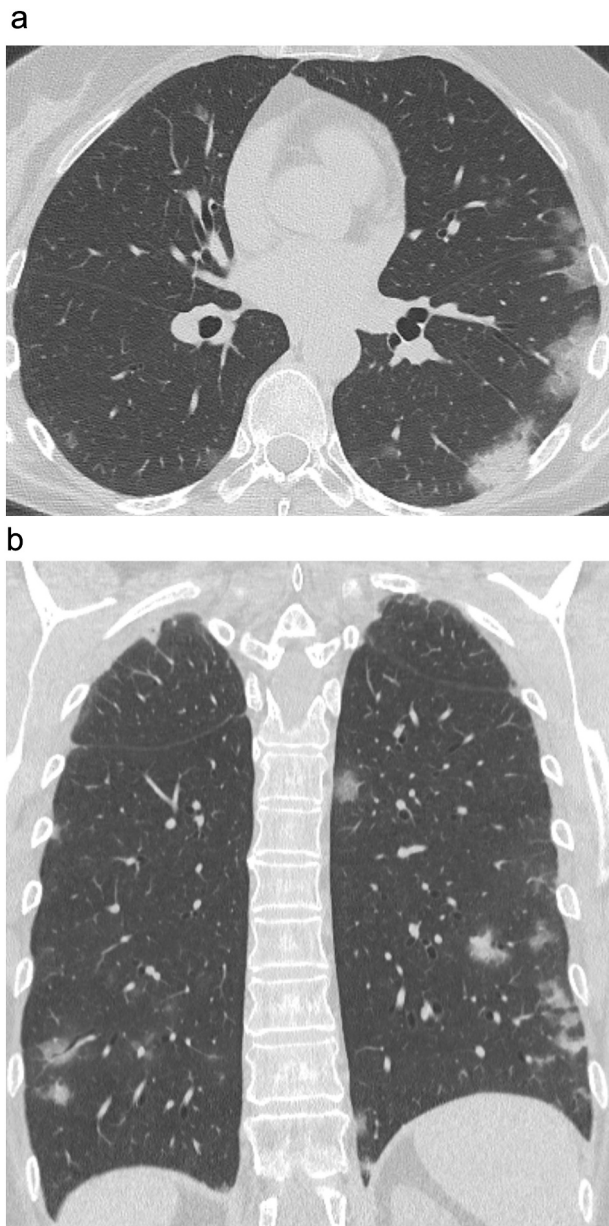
COVID-19 pneumonia with mild disease extent in a 60-year-old female patient. HRCT images on the axial (a) and coronal (b) planes show peripheral, multifocal, bilateral ground-glass opacities, mainly involving the lower lobes. Computed tomography involvement scores were 5/24 for radiology resident 1, 5/24 for radiology resident 2, and 4/24 for the chest-devoted radiologist. All the readers defined the appearance as “typical” according to the Radiological Society of North America categorization. The patient was discharged from the hospital the same day as the HRCT was made.
